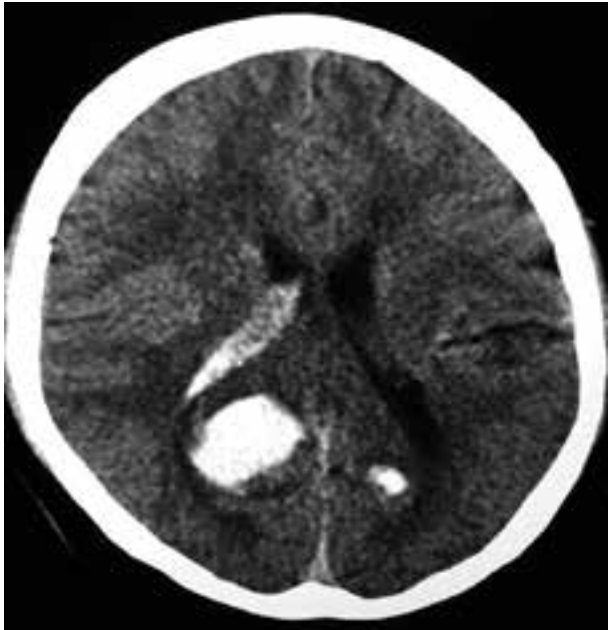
CT Brain showed bilateral occipital fresh intracerebral haematoma
